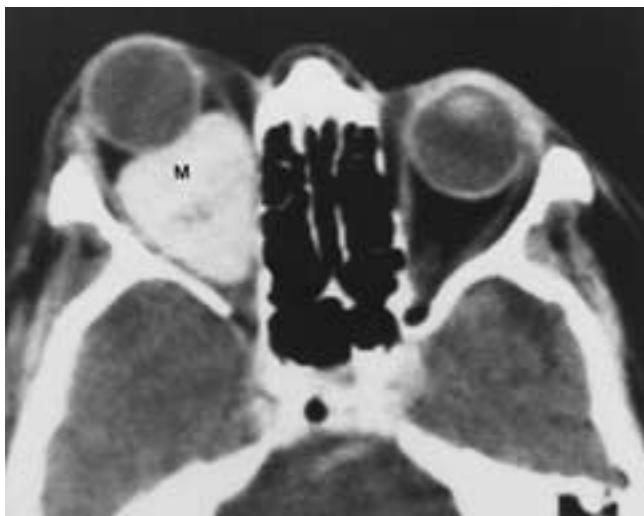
Orbital schwannoma. Contrast-enhanced axial CT scan shows a large enhancing mass (M).
